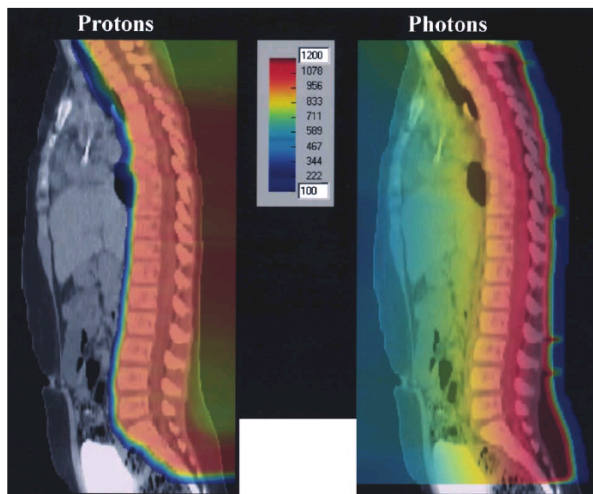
Treatment of a young patient with medulloblastoma; from [Sui03]. The image on the right side shows the irradiation with the conventional posterior 4 MV X-ray beam and resultant intermediate high dose to the anterior tissues/organs. The image on the left shows the treatment by a posterior proton beam which delivers nearly zero dose to all tissues anterior to the anterior surface of the vertebral bodies.
